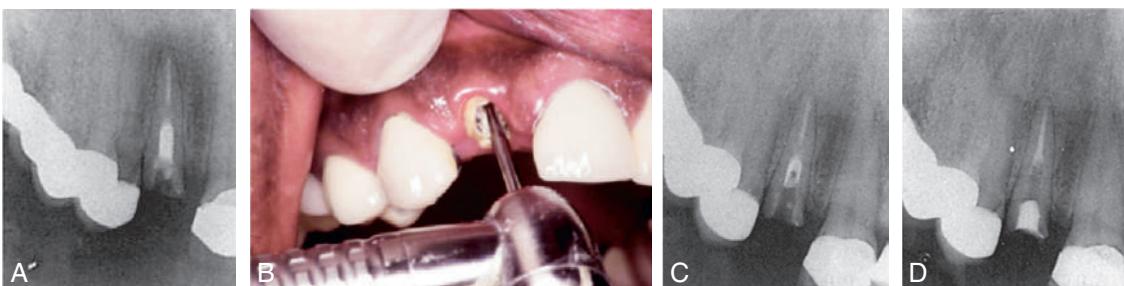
Post removal by high-speed bur. (A) Preoperative radiograph of the right maxillary lateral incisor, in which both the crown and part of a post have been fractured off. A portion of the parallel-sided, threaded post remains within the canal. (B) Because of the large diameter of the post and its position within the canal, a high-speed handpiece was chosen to drill it out. (C) Radiograph to verify the correct orientation of the bur's progress inside the canal. With this method of post removal, the operator must be extremely careful not to let the high-speed bur contact the canal wall, which would seriously compromise tooth structure. (D) Radiograph of the incisor after post removal and re-treatment. (Courtesy Dr. D.A. Miller.)
